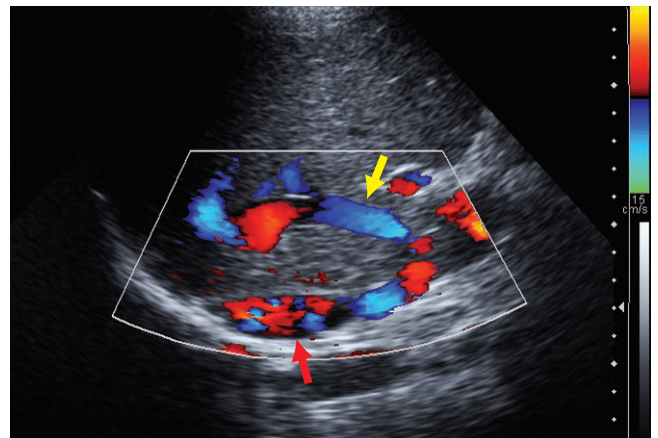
The sagittal color Doppler image of the liver shows a dilated caudate vein (yellow arrow) draining into the IVC (red arrow).
